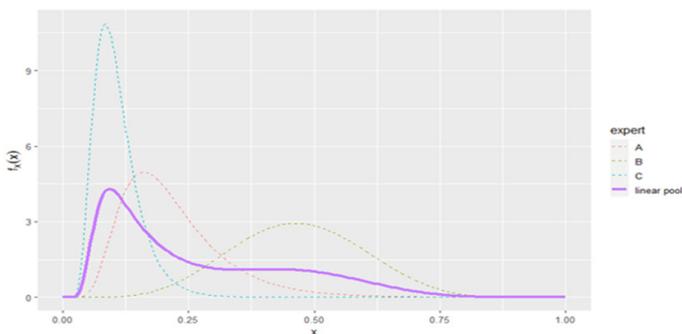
The three fitted distributions (proportion of patients undergoing brain CT scan) and an equal-weighted linear pool.
